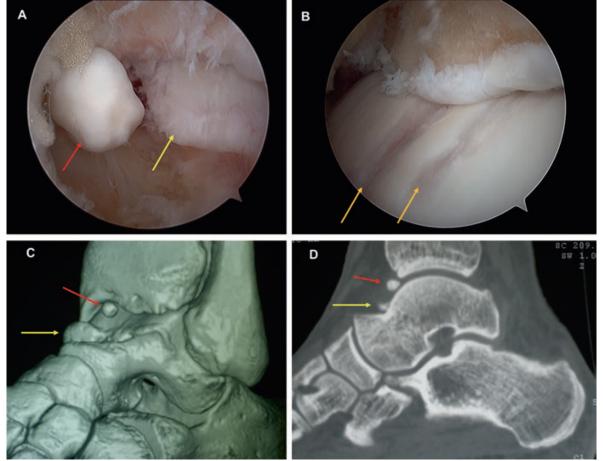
(A, B) Arthroscopic view of loose body (red arrow) and talar spur (yellow arrow), causing osteochondral ridge defects (orange arrow on the talar dome). (C, D) CT view of the loose body (red arrow) and talar spur (yellow arrow)
